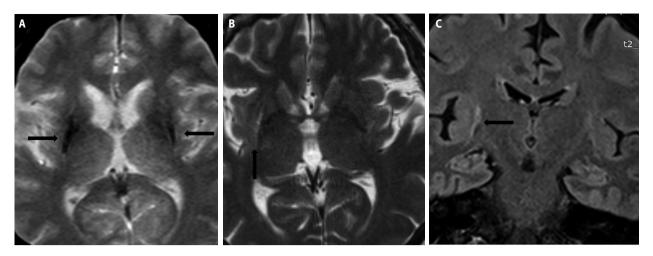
MRI, MSA with parkinsonism. A. Axial, T2*GRE; bilateral putaminal hypointensity and atrophy with loss of normal convex outer margin of putamen (arrows) – right putamen more affected than left; B. Axial T2WI; C. Coronal FLAIR – 'slit-like' hyperintensity along lateral margin of right putamen (arrows)
